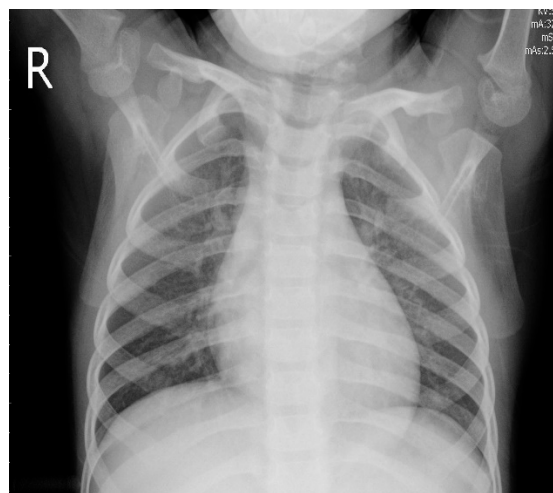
X-ray image of viral pneumonia patient.
